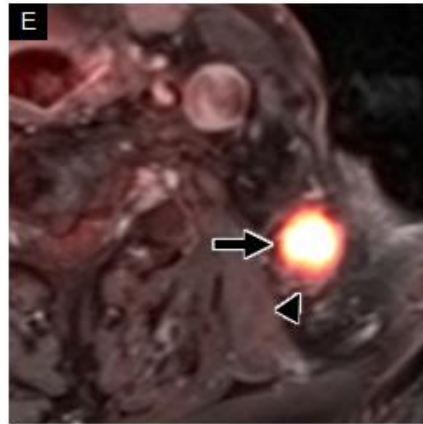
75-year-old male with invasive squamous cell carcinoma of the left temporal scalp. Axial NECT (A) shows an invasive left preauricular skin cancer (white arrow) with deep invasion into the subcutaneous tissues. Axial 18F-FDG PET/CT (B) demonstrates marked FDG avidity within the primary tumor (black arrow), which was subsequently resected. A follow up axial CECT performed 3 years later (C) shows a highly concerning, enlarged left level V lymph node (white arrow) with rounded morphology and loss of fatty hilum. Axial T1WI C+ FS (D) shows this lymph node to have concerning heterogeneous hyperenhancement (white arrow), including shaggy enhancement at its margin (white arrowhead), concerning for extranodal extension (ENE) of tumor. Axial 18F-FDG PET/MRI with fused T1WI C+ FS (E) shows associated hypermetabolism within the level V node (black arrow), as well as mildly increased FDG uptake in the adjacent enhancing soft tissue (black arrowhead), which remains concerning for ENE.
